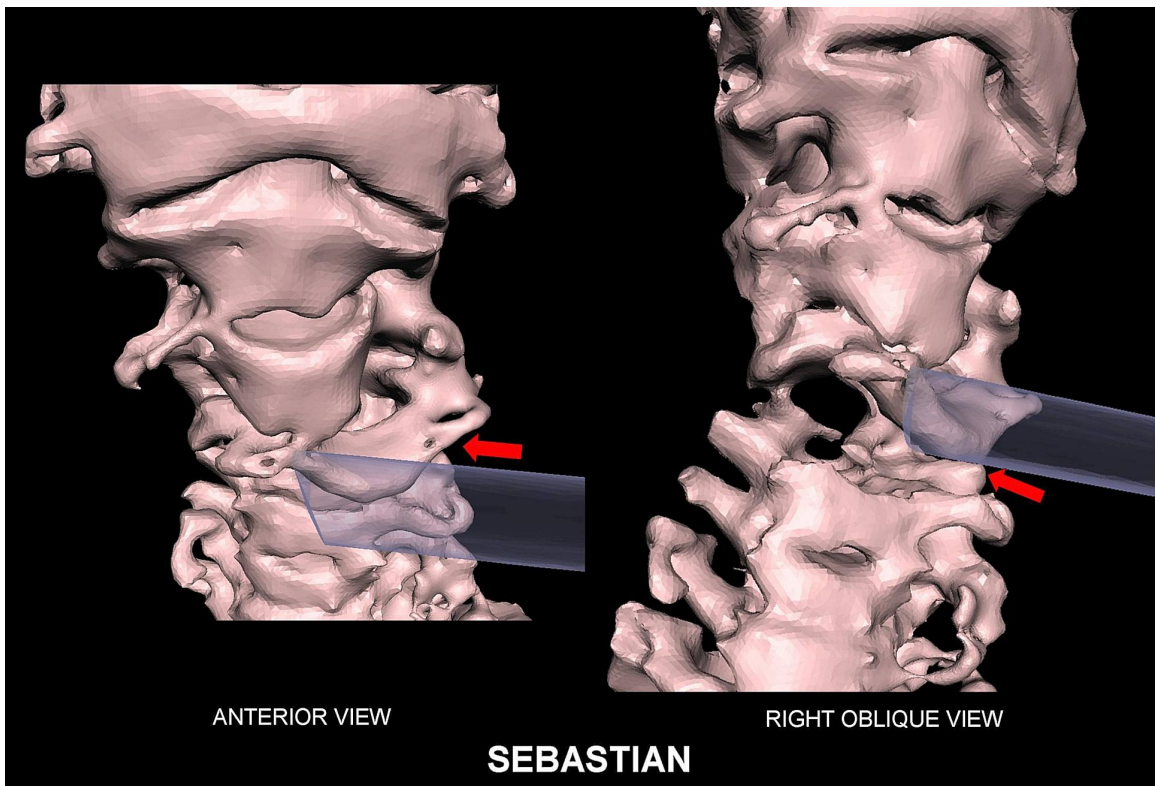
3D CT showing frontal (*left*) and right oblique (*right*) views of cervical spine. Anterior displacement with rotary subluxation of C4 vertebra (*red arrow*) was evidence. Proposed trajectory of injuring object was shown in semi-transparency.
